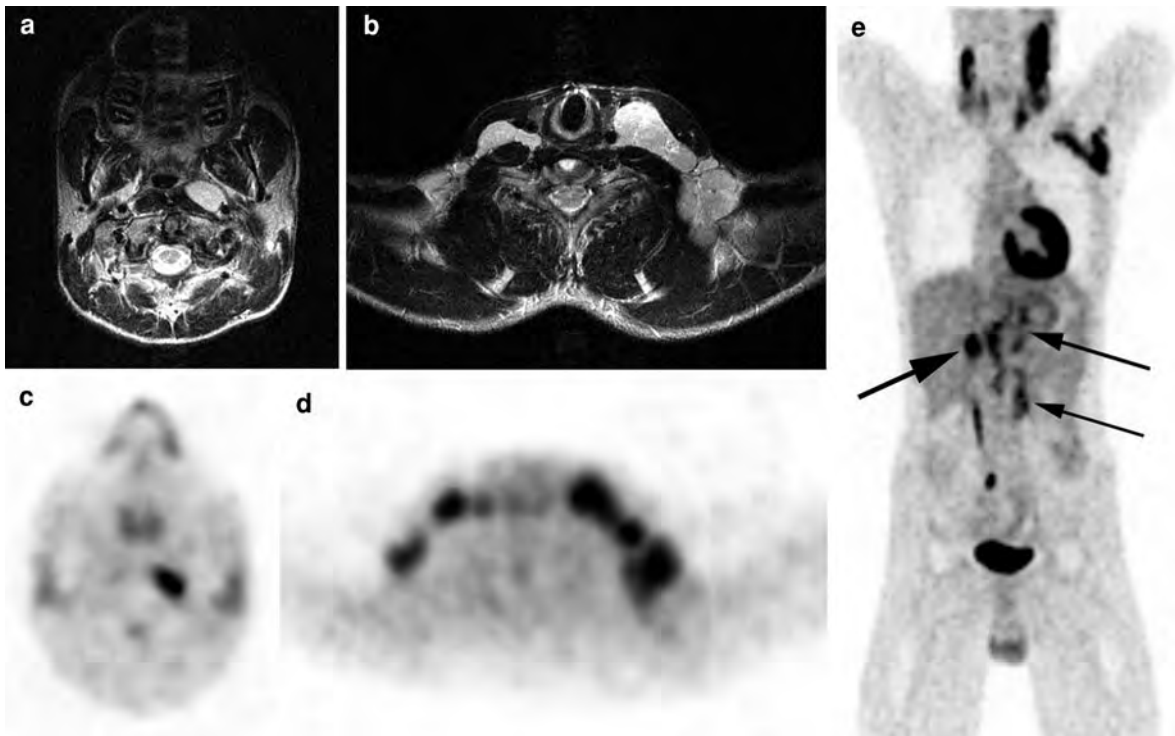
Patient with Hodgkin's lymphoma (HL). Initial staging with MRI of the neck shows extensive lymphadenopathy. a Enlarged left retropharyngeal node. b Bilateral neck and left axillary adenopathy (presenting symptom). PET study confirms the MR-findings in the neck (c and d). e Periaortic lymph nodes
